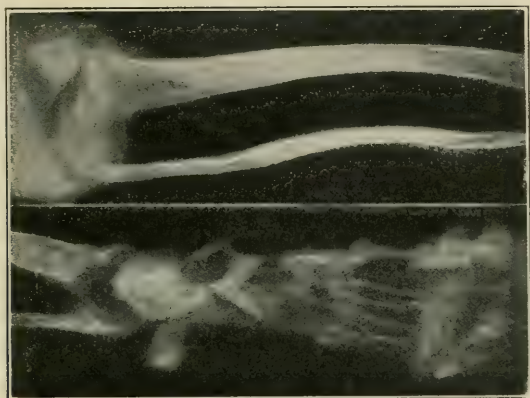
X-ray showing bone changes in Fig. 25.
